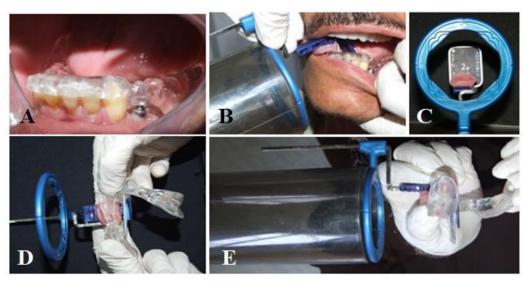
The surgical guide (template) (A), Positioning of plastic bite blocks of the Dentsply/Rinn XCP instruments for standardization of digital periapical radiograph after some modification (B), The Dentsply/Rinn XCP instruments allow the sensor to be centralized (C), Accurately positioned in relation to the radiographic template (D), X-ray parallel cone (E).
